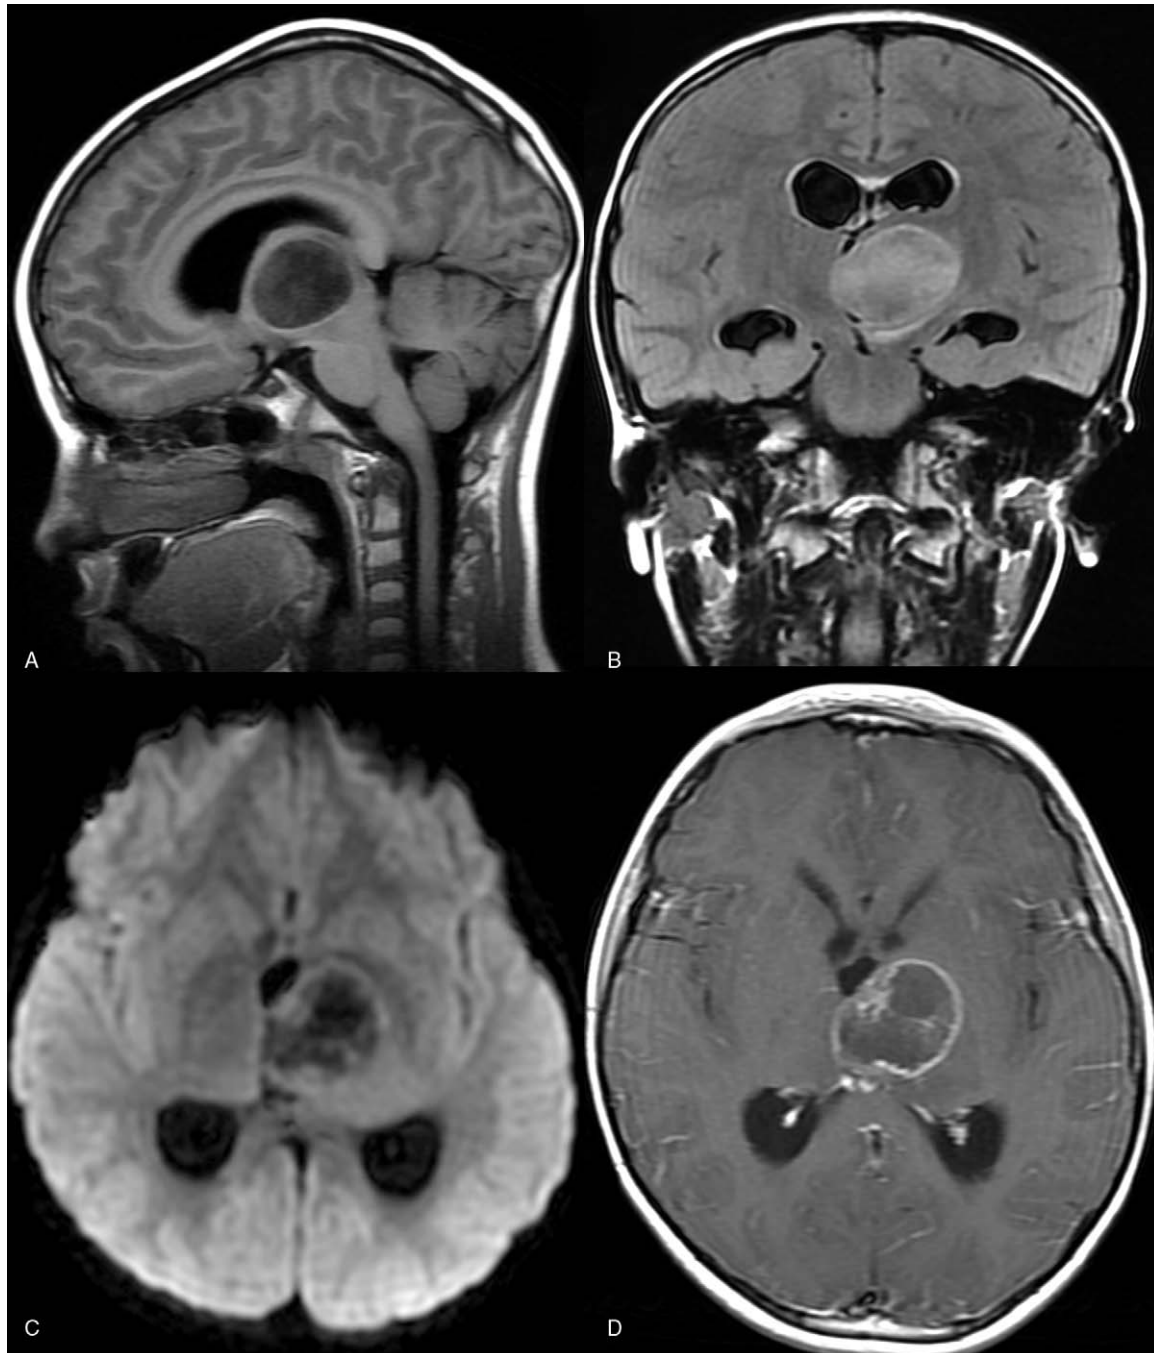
A 12-year-old patient with diffuse midline glioma of the left thalamus. Sagittal T1-weighted and coronal FLAIR (B) images a mass centered in the left thalamus bulging into the third ventricle. There is heterogeneous diffusion with mild restricted diffusion in the rim (C). Postcontrast T1-weighted images (D) show heterogeneous enhancement with a thin enhancing rim and central nonenhancement/necrosis.
